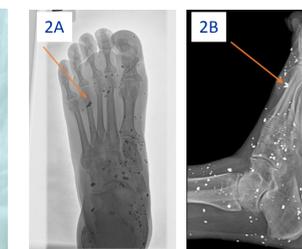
AP plain film radiograph
